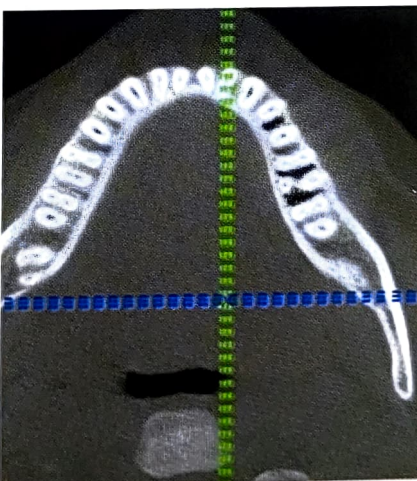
CBCT demonstrates axial 2-D slices of 36 showing extra root; Middle third
